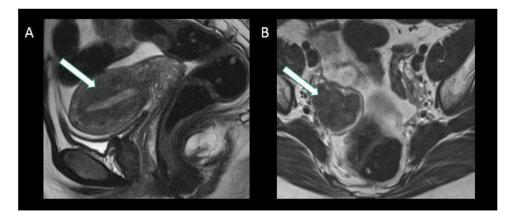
(A) Sagittal T2-weighted image showing anteverted uterus with normal endo-myometrial interface. (B) Axial T2-weighted image showing lobulated hypointense lesion in right ovary (white arrow) and normal left ovary (yellow arrow). Signal intensity of the lesion is same as that of the uterine myometrium.
